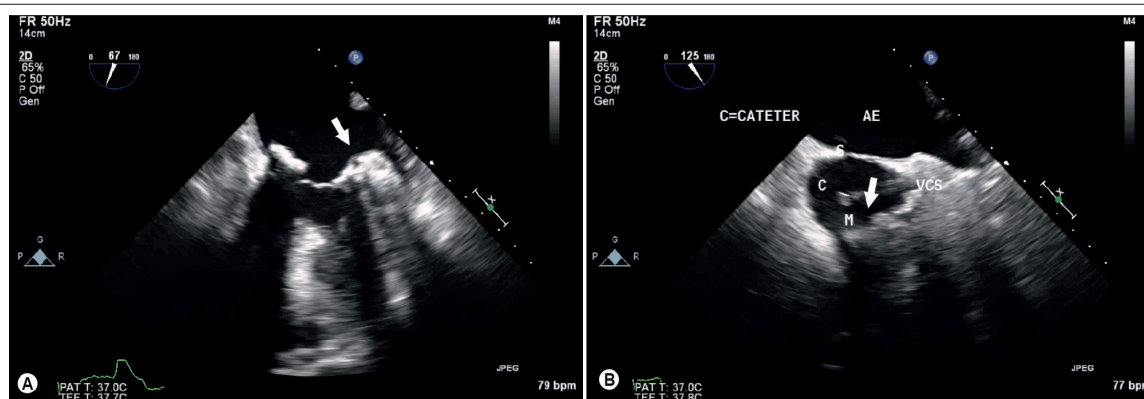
Transesophageal echocardiogram (TEE). A – mass attached (white arrow) to the left atrial wall, adjacent to mitral valve annulus, measuring 22 mm. B – mass (white arrow) attached to the right atrium, adjacent to the opening of superior vena cava. C = central line catheter, LA – left atrium, S = interatrial septum, M = mass, SVC = superior vena cava.
